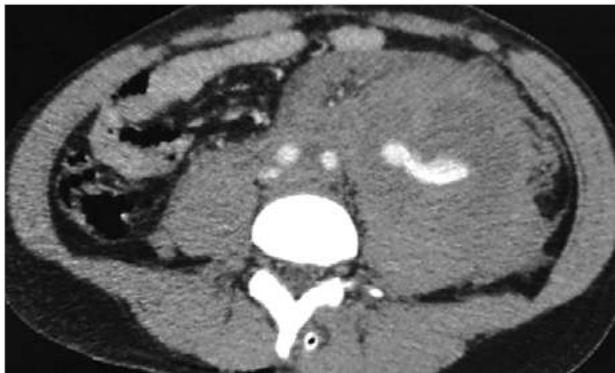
CT images of contrast extravasation and retroperitoneal hematoma
